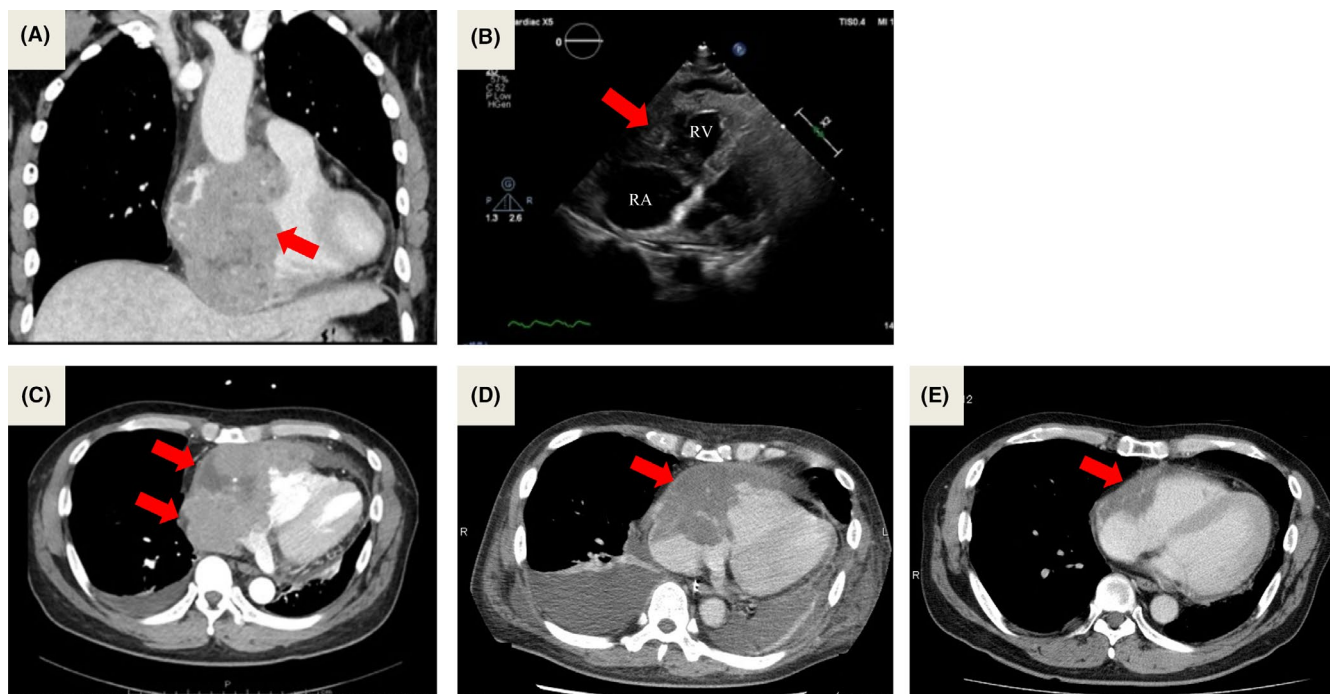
A, The reconstructed coronal view of the chest CT revealed a right atrial mass. B, Echocardiography showed a mass in his right atrium and ventricle. C, Contrast-enhanced CT revealed heterogeneous enhancement in his right atrium and ventricle (arrow). D, Contrast-enhanced CT showed a tumor in his right atrium and ventricle decreased by 30–40% after the first chemotherapy. E, Contrast-enhanced CT revealed a tumor in his right atrium and ventricle decreased by 70–80% after the first chemotherapy after the rituximab-combined CHOP therapy six times. RA, right atrium; RV, right ventricle
